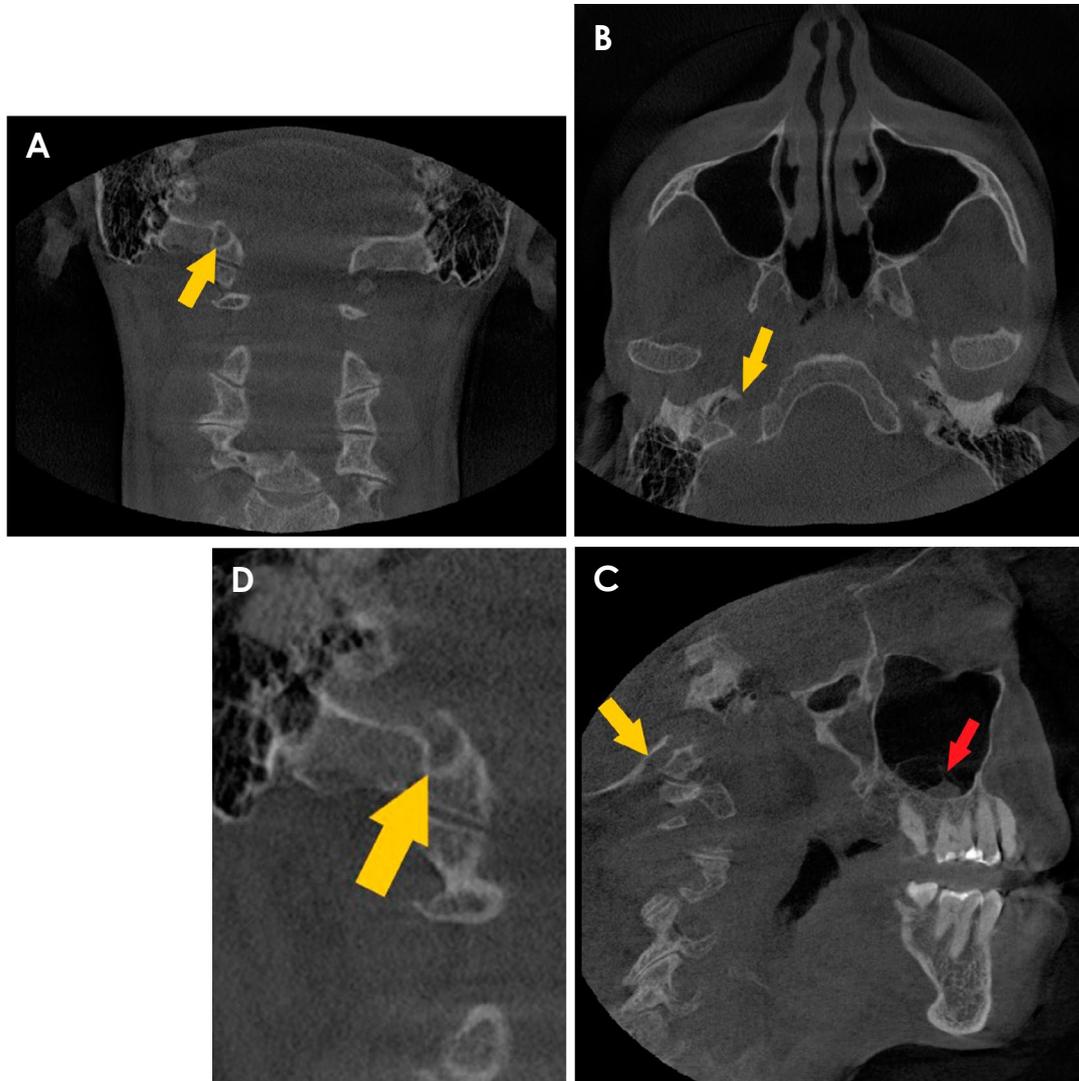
A. A coronal cone-beam computed tomographic (CBCT) image shows extension of the right jugular bulb into the ipsilateral occipital condyle. B. An axial CBCT image demonstrates maintenance of the jugular spine. C. A sagittal CBCT image depicts expansion of the jugular bulb into the occipital condyle (yellow arrow) and an incidental finding of sinusitis of the right maxillary sinus (red arrow). D. A sagittal CBCT image clearly indicates a dilated jugular bulb.
